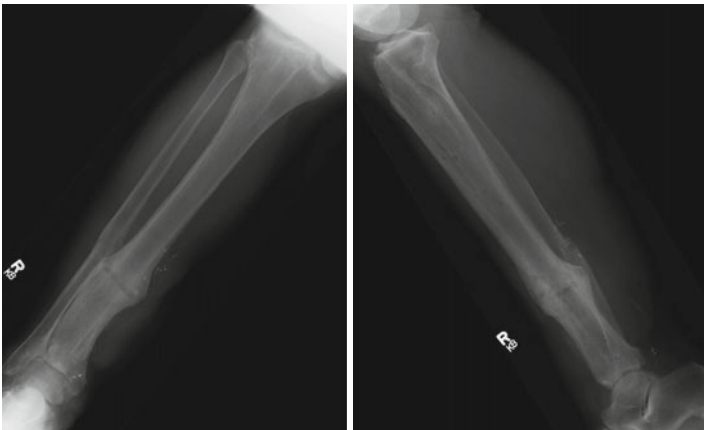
Eight-month postoperative radiographs
